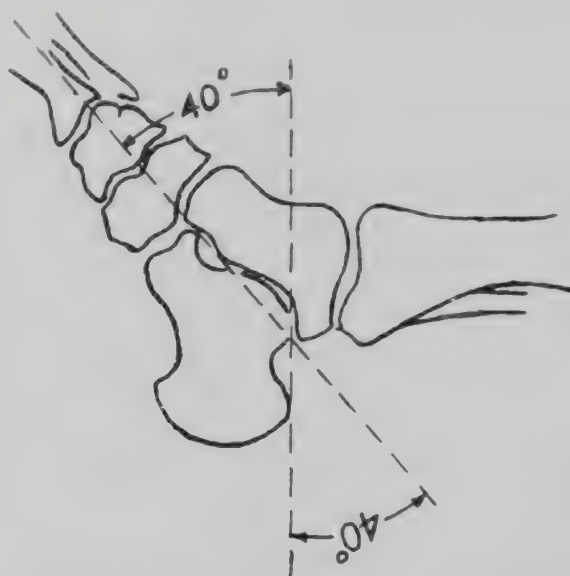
Boehler's angle. (Sante, L. R.: Manual of Roentgenological Technique, Edwards Brothers.)
